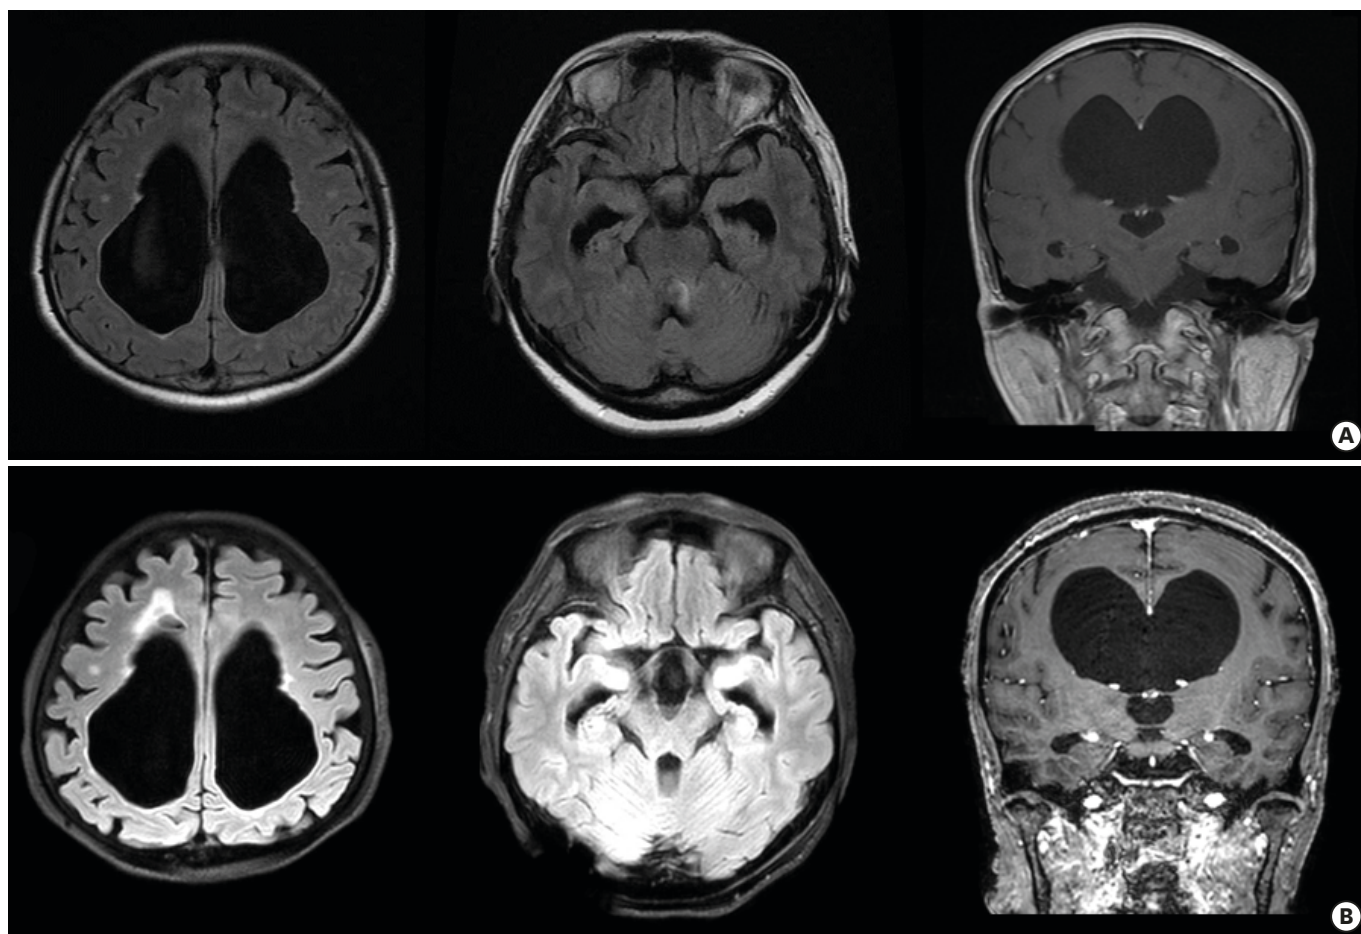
Brain magnetic resonance imaging at diagnosis and follow-up. Fluid-attenuated inversion recovery images showed severe ventriculomegaly at diagnosis (A). There is no change in ventriculomegaly 9 years after insertion of the ventriculoperitoneal shunt (B).
